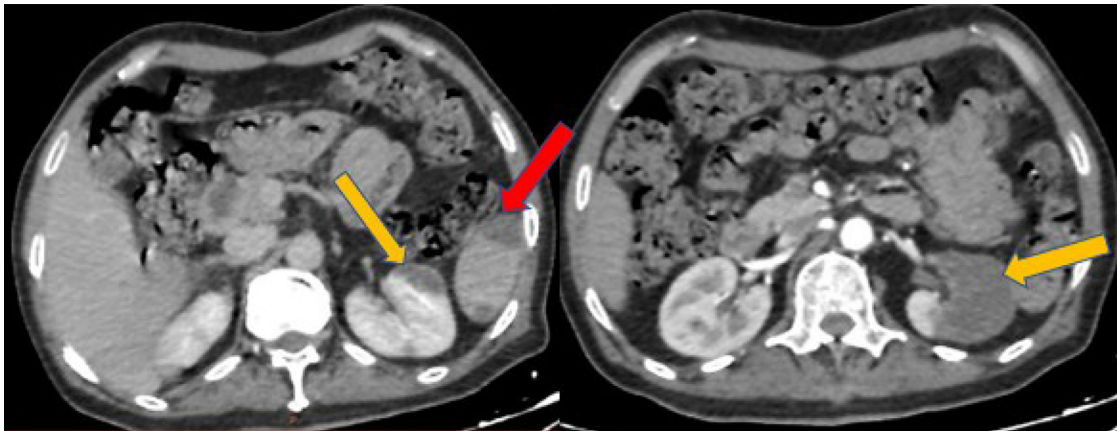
abdominal CTA in axial reformatting showing left renal infarction (yellow arrows) and splenic infarction. (Red arrow).
